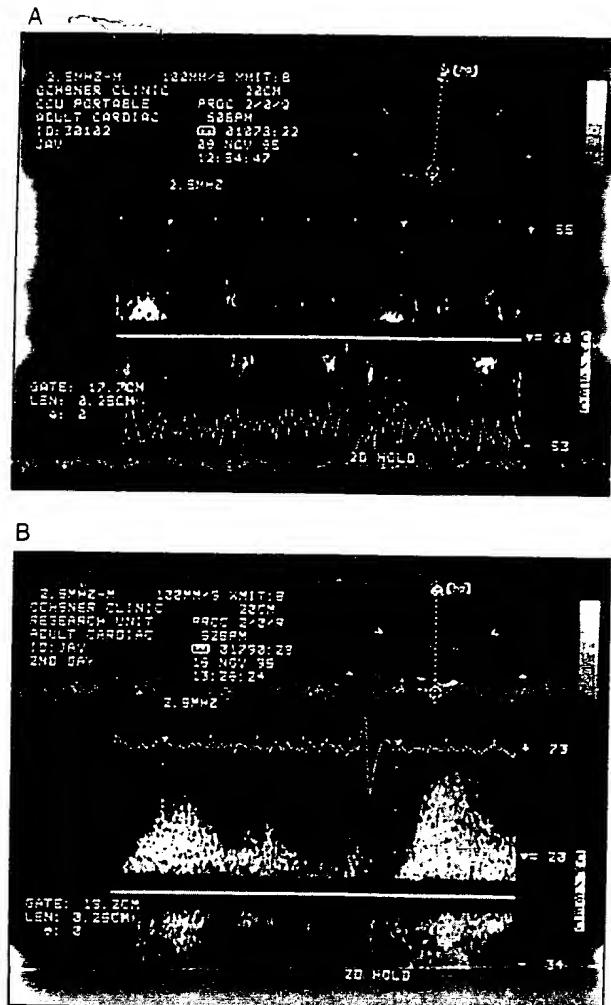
Right pulmonary vein pulsed wave Doppler before (A) and after (B) Optison.
